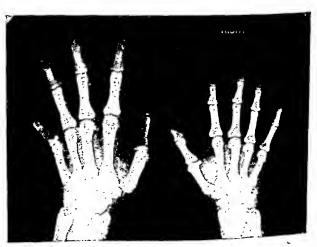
Roentgenogram of Hand in comparison with that of a normal average-sized adult.
